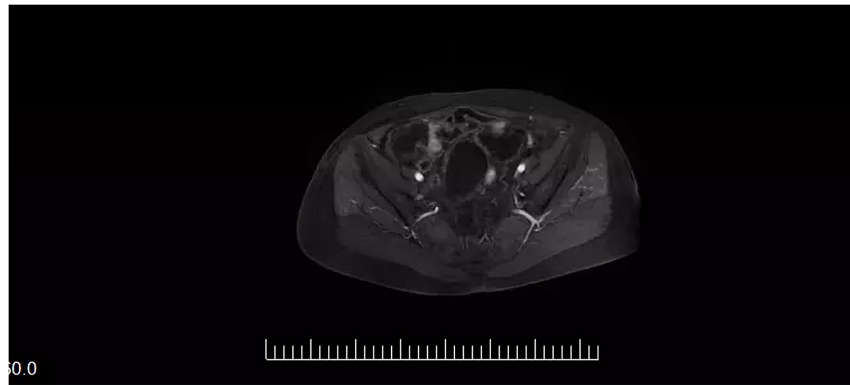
MRI Ax LAVA+C image: The small nodular and small strip-shaped low-signal shadows are enhanced, and the diffusely thickened peritoneum is enhanced.
